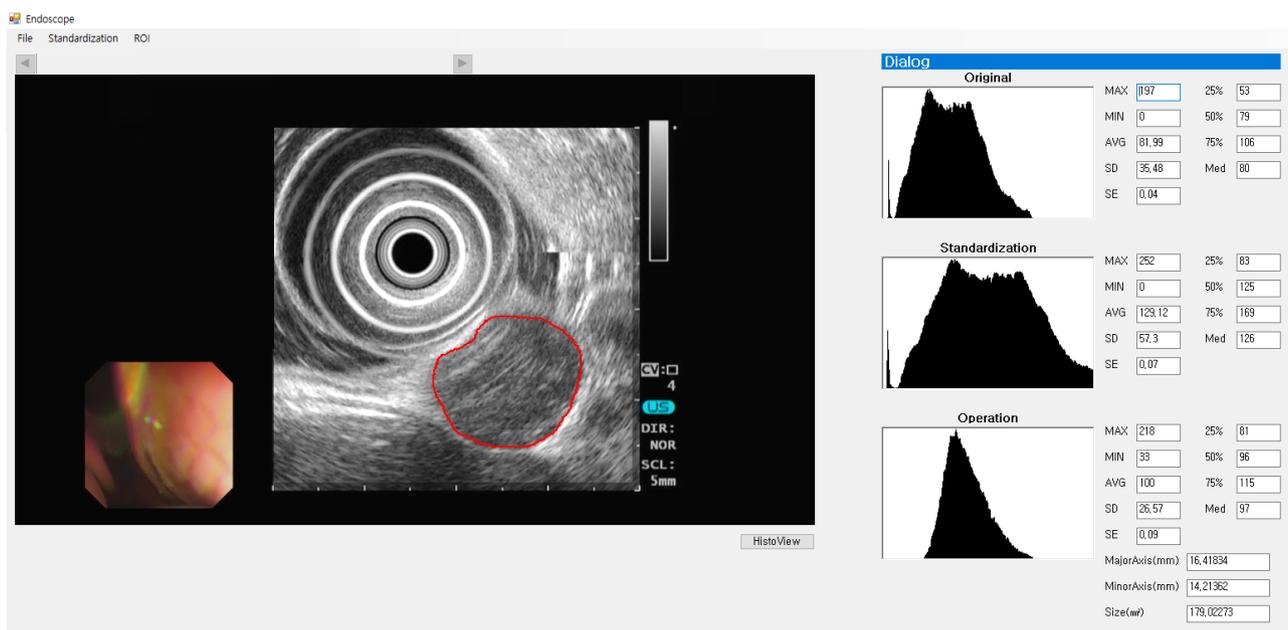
Example of digital endoscopic ultrasonography image analysis of a gastric mesenchymal tumor. From the standardized image, a region of interest (ROI) is selected by an endoscopist for tumor analysis. The results for the ROI are expressed in the bottom histogram. The mean and standard deviation of the brightness values are 96 and 26.57, respectively.
